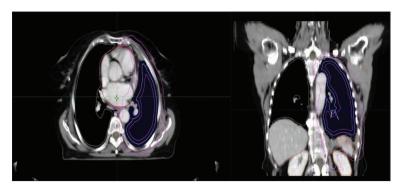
4D computed tomography of the thorax; target volume delineation and organs at risk; gross tumor volume – orange contour at coronal slice; clinical target volume – light pink contour; planning target volume – purple contour; organs at risk: spinal column – yellow contour; esophagus – brown contour; heart – red contour; both lungs delineated, both kidneys and liver (Institute for Oncology and Radiology of Serbia)
